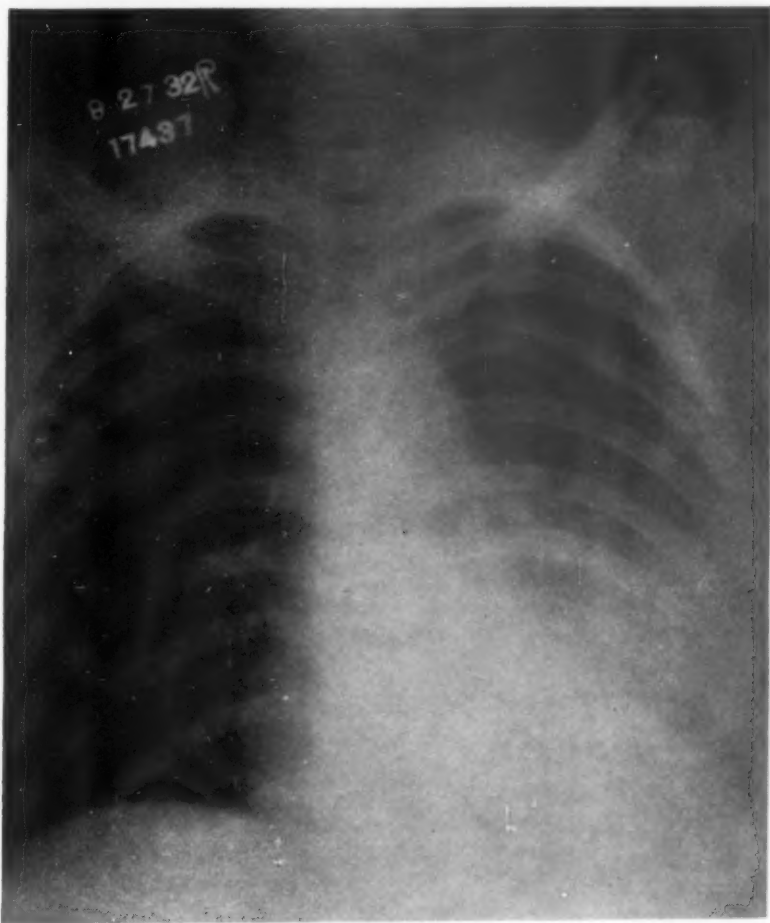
Roentgenogram taken on the ninth day of illness, showing extension of pathologic process in lower left lobe.
